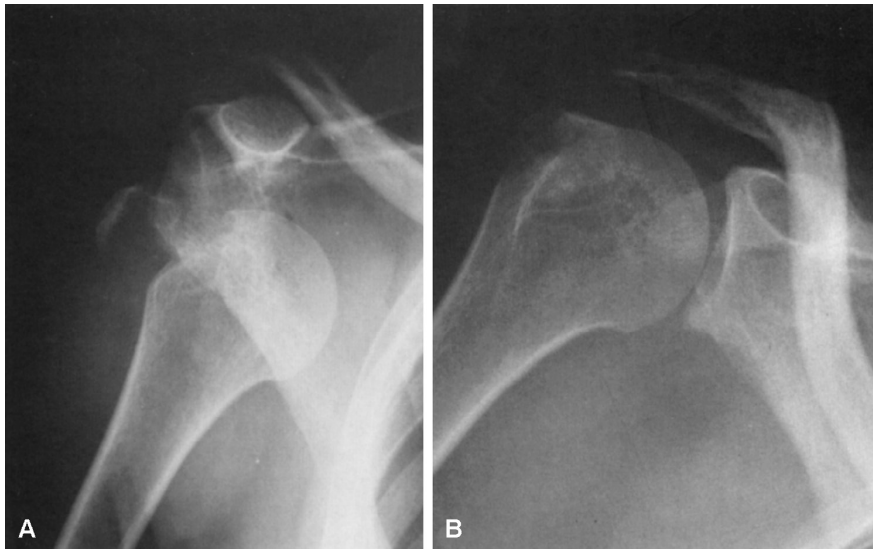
A, Anteroposterior x-ray film of a two-part anterior fracture-dislocation with a displaced greater tuberosity fracture. B, After a closed reduction, the greater tuberosity fracture reduced and healed without further displacement. (From Rockwood CA, Green DP, Bucholz RW, Heckman JD: *Fractures in adults*, ed 4, p 1069, Philadelphia, 1996, Lippincott-Raven.)
